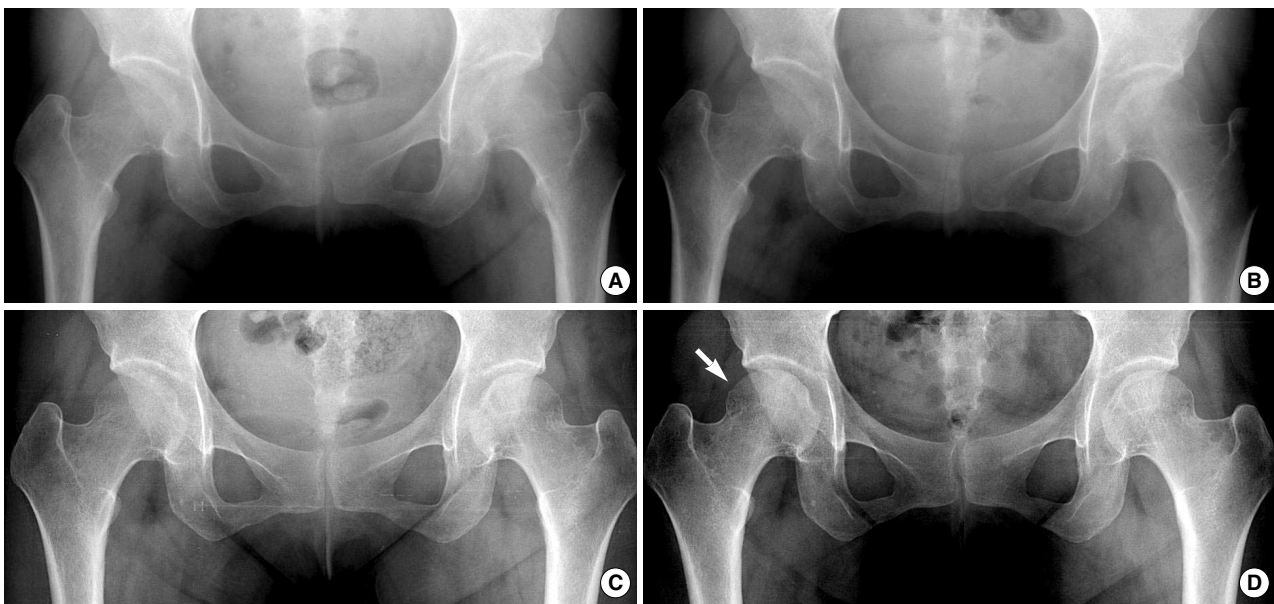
A 28-yr-old woman with pain in both hips, which occurred at gestation 32 weeks in the left hip and immediately after delivery in the right. Anteroposterior radiograph obtained 1 week postpartum shows marked osteopenia in both proximal femurs.
